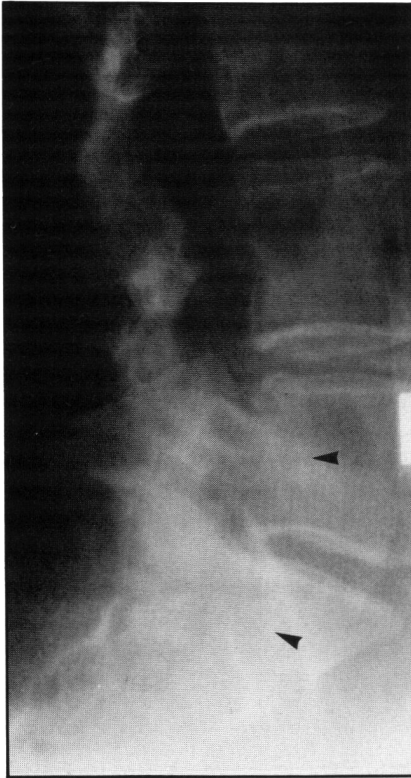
Plain x-rays of lumbosacral spine. Note the scalloped erosions of the posterior aspects of the bodies of L5 and S1 (arrows).
